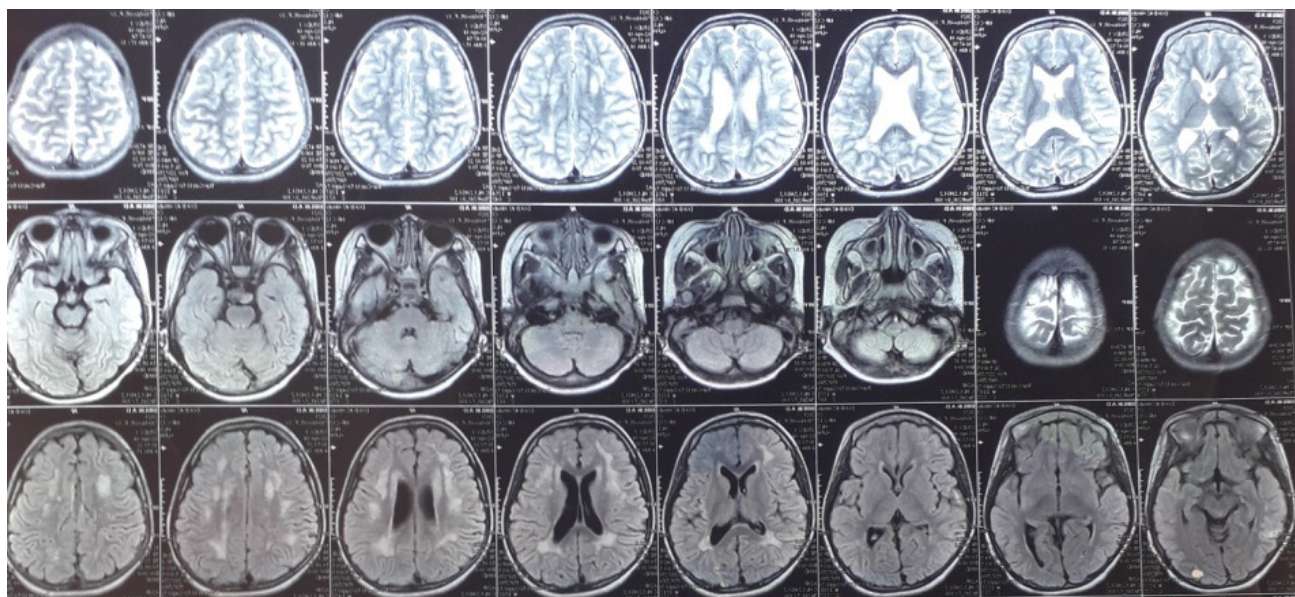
Computer tomography of a brain in a series of CT scans – The sulci convexity is smoothed. The subarachnoid cavity in the parietal-frontal space is expanded. Parasagittal and Midline structures are not displaced. In periventricular sections of the brain, decreased density of white matter zones up to 10-20 Hanzfield units. Moderate and symmetrical expansion of the tricorn is noted. Parasellar sections, cerebellum, and orbits are not changed.
